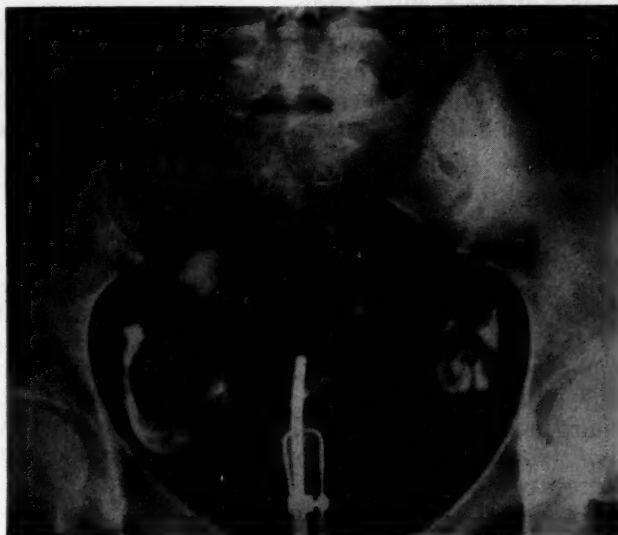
X-ray plate of the pelvis after instillation of 6 c.c. of Medopaque-H followed by some carbon dioxide. The opaque medium can be seen free in the pelvic cavity.
